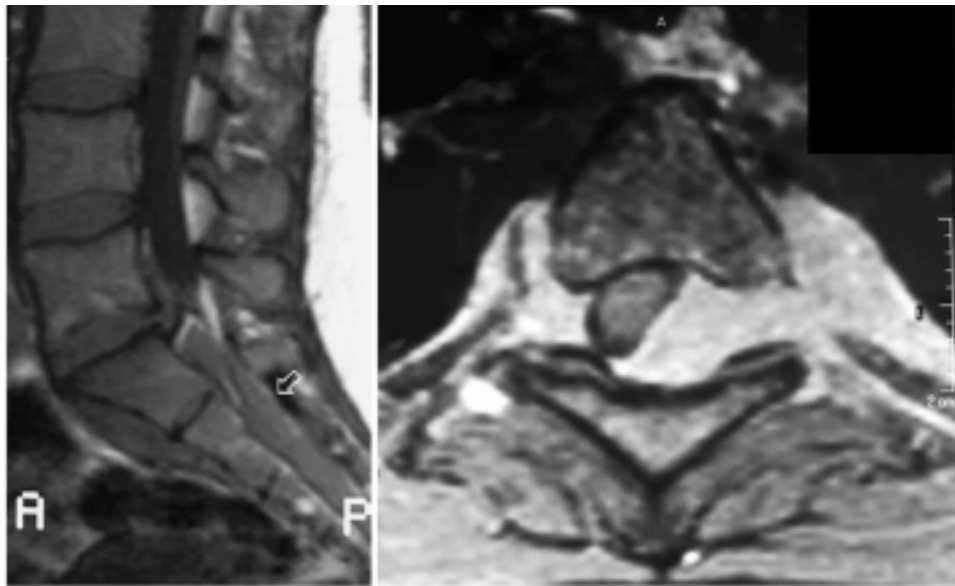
Left:* Sagittal T₁-weighted MR image revealing an intraspinal, intradural, isodense mass between S-1 and S-4 (*arrow*). *Right:* Axial fat-saturation Gd-enhanced T₁-weighted MR image demonstrating a homogeneously enhancing intraspinal, intradural, extramedullary lesion at T3-5 with significant compression of the spinal cord from the left dorsal aspect of the lesion.
